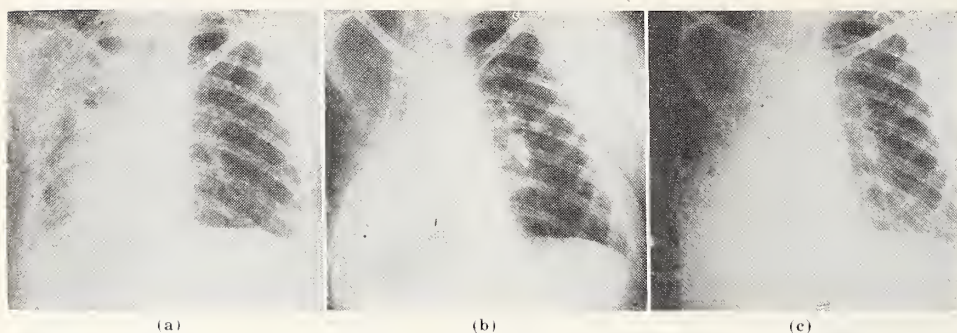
(Case No. 5) (a). X-rays showing bilateral pulmonary tuberculosis with much destruction of the left lung, (b) following thoracoplasty and (c) following left pneumonectomy.
